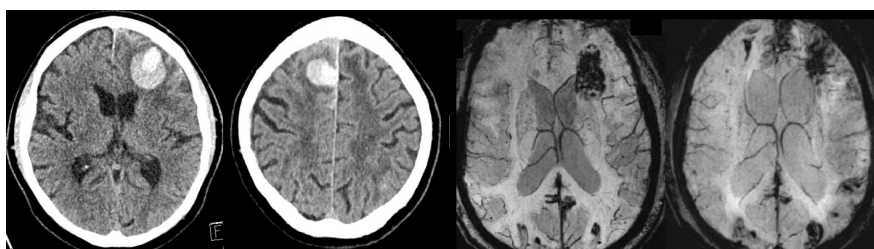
Primary cerebral amyloid angiopathy. An 80-y/o with ICH separated in time and location. CT scans performed on the left when the patient presented with Parkinsonian features, gait difficulty and progressive confusion, compared with 7 months later when more noticeable abrupt confusion was noted (second image from the left), arriving at the physical therapy appointment without shoes and not following instructions. MRI scans taken two years apart show progression of hemosiderin deposits on SWI in both hemispheres, with enlargement of the ventricles (as shown in the two images to the right).
